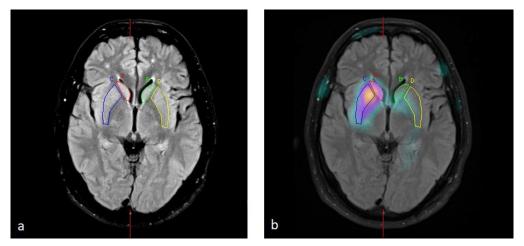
ROIs drawn above basal ganglia subregions in the same subject shown in Figure 1b. presenting with right tremor demonstrating prominent decreased radiotracer uptake of the left basal ganglia. (a) ROI on MRI images, (b) ROI on co-registered MRI/SPECT images; A, right caudate; B, left caudate; C, right putamen; D, left putamen.
